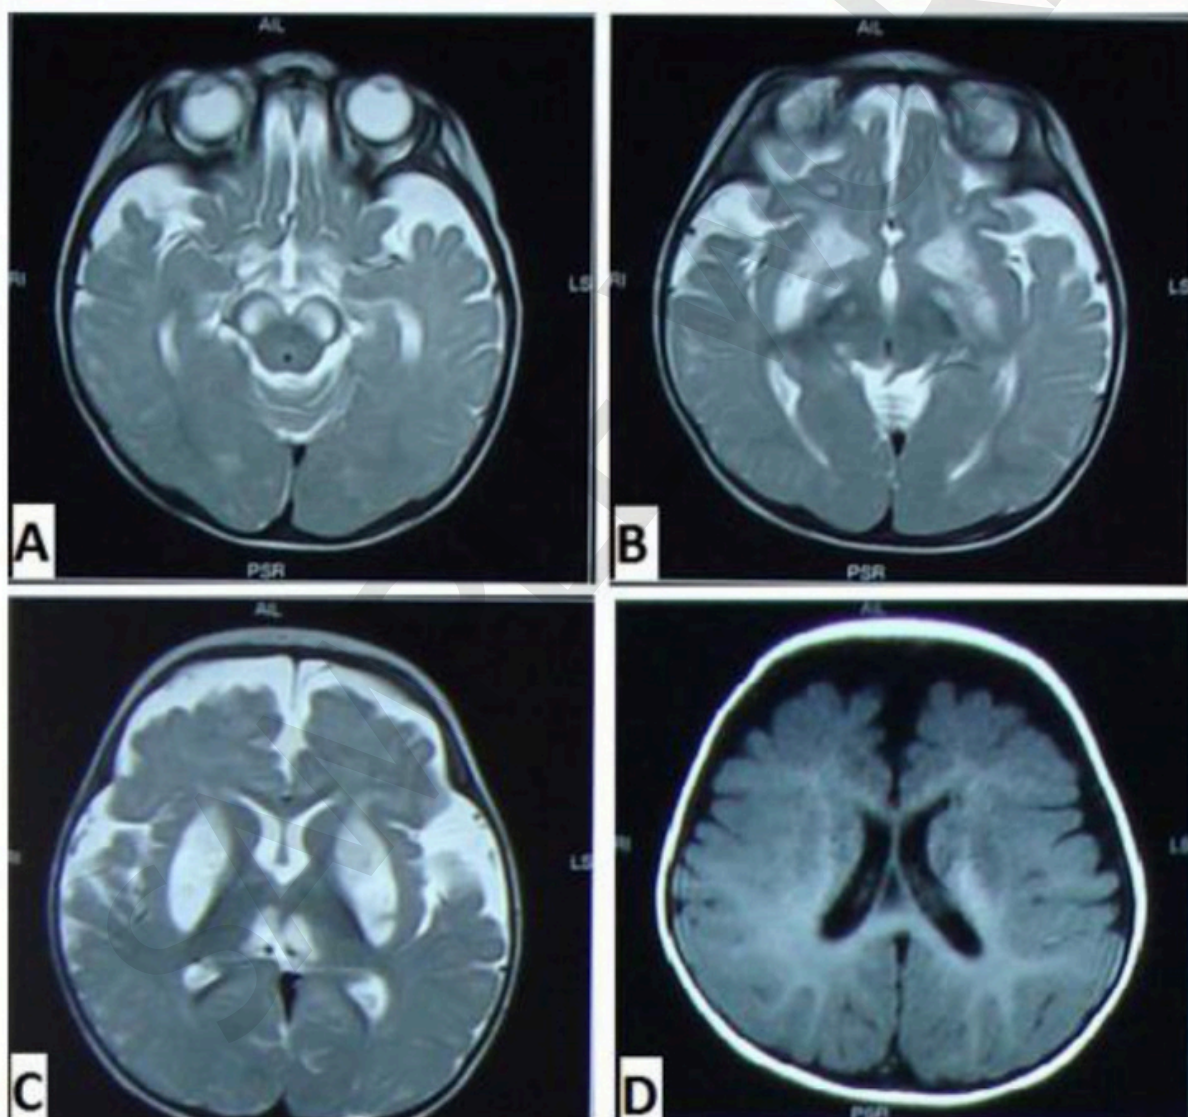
MRI Findings of Leigh Syndrome. A & B: T2W image showing bilateral symmetrical abnormal signal intensities, seen in cerebral peduncles, dorsal medulla and peri aqueduct grey matter. C: T2W image showing bilateral symmetrical abnormal signal intensities, seen involving basal ganglia and thalami. D: T2W image showing prominent extracerebral CSF spaces in front-temporo-parietal region on both sides depicting signs of frontal atrophy
